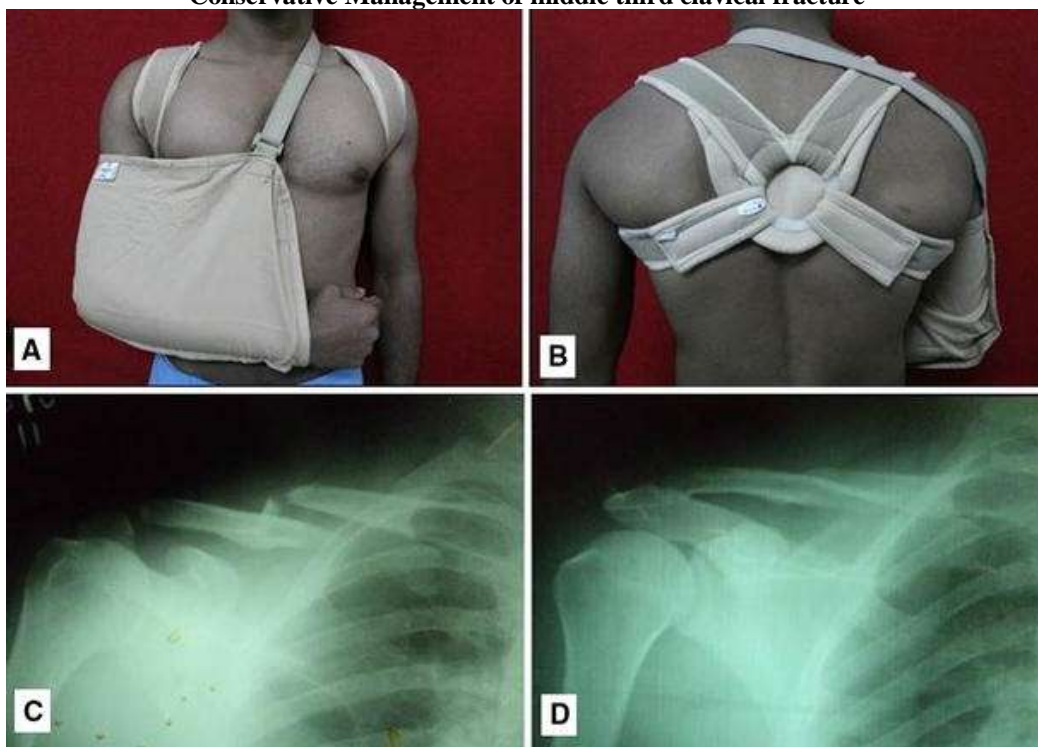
Image showing (a) & (b) showing broad arm pouch sling with figure of eight bandage, (c) immediate xray after trauma (d) xray of clavical fracture at three month follow up of conservative management.
